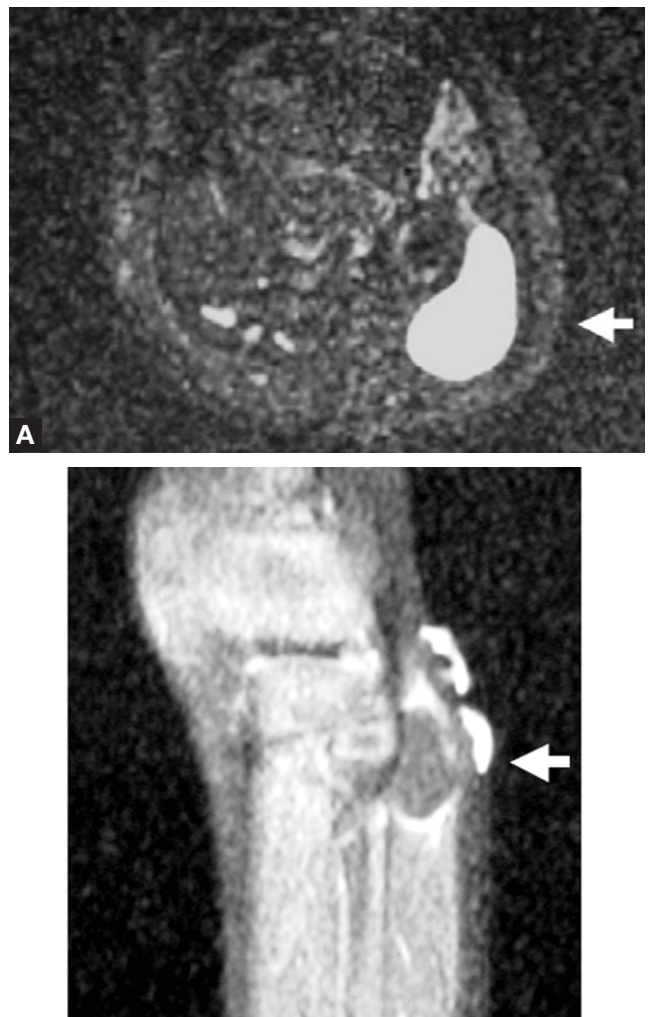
(A) An axial T₂-weighted magnetic resonance image demonstrates a cystic mass adjacent to the posterior and lateral aspects of the fibular neck (arrow). (B) A sagittal T₁-weighted magnetic resonance image with fat saturation following contrast shows a cystic mass at the level of the fibular neck (arrow).
